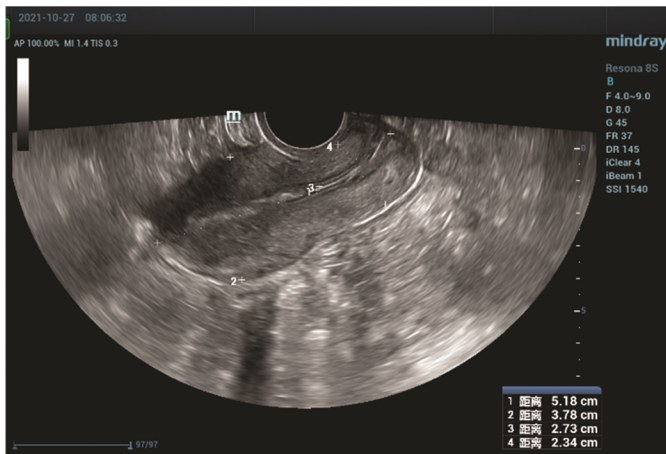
Measurement of cervical thickness on a transvaginal ultrasound image. Measurements obtained in the mid-sagittal plane along the axis of the cervix are shown. Point a: the internal os; point b: the external os; point c: the midpoint of the cervical canal; distance 1 (hallow arrow): the cervical length; distance 2 (solid arrow): the cervical thickness
